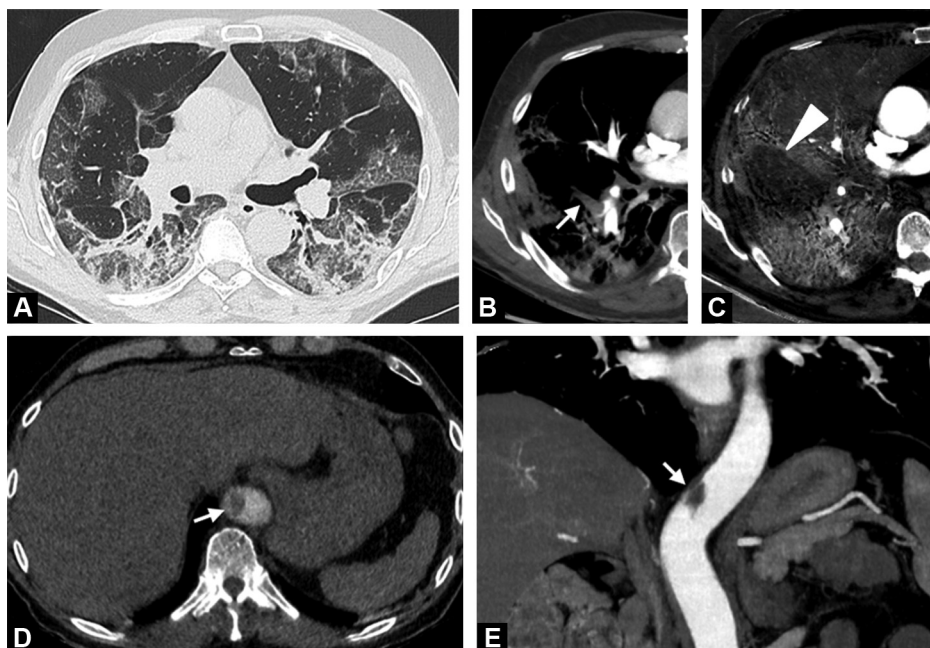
71-year-old man with COVID-19 pneumonia. A. Unenhanced CT image of the chest in the axial plane obtained at admission shows bilateral and peripheral ground-glass opacities associated with posterior consolidations. B. Dual-energy CT angiography image of the chest in the axial plane on hospital day 3 shows a filling defect (arrow) in the anterior basal branch of the right inferior lobe pulmonary artery. C. Iodine map image demonstrates a segmental perfusion defect (arrowhead) related to the occlusive pulmonary embolism in the right lower lobe. D. CT angiography image of the chest in the axial plane reveals a filling defect (arrow) within the aorta. E. CT angiography image of the abdominal aorta in the coronal plane performed on hospital day 3 confirms intra-aortic free-floating thrombus (arrow) at the thoraco-abdominal junction.
